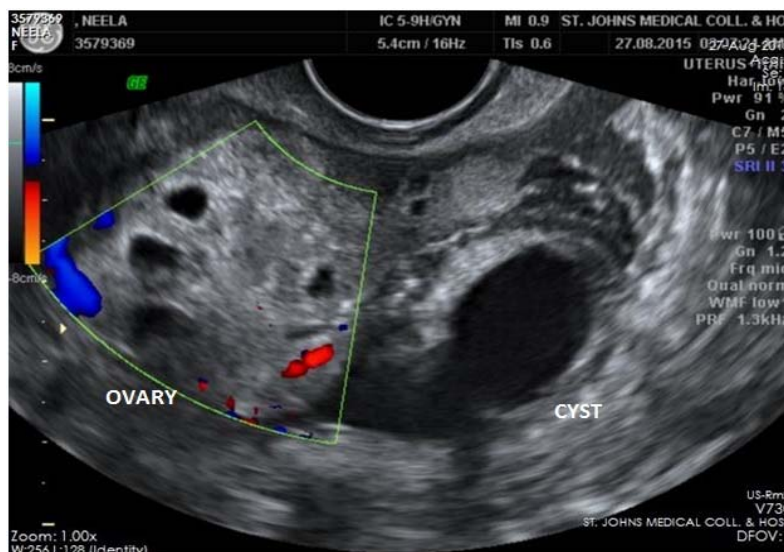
Transvaginal ultrasound showing bulky right ovary & paraovarian cyst
